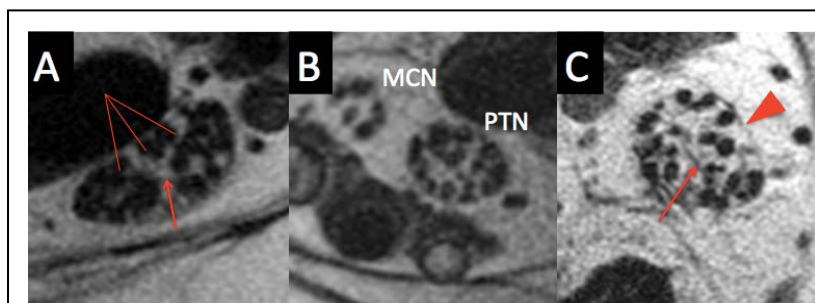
2D TSE T1-weighted with approximately 100 μ m resolution. Posterior tibial nerves at the ankle from different patients. [A] Suspected tarsal tunnel syndrome with mild neuropathy. [B] Mild diabetic neuropathy. [C] Severe amyloid related neuropathy. The fascicles (straight lines) are interspersed with a variable amount of epineurial fat, seen bright. Fibrous epineurium (long arrow) and paraneural fascia (arrowhead) are also seen, with low signal. Note the separation of the medial calcaneal nerve (MCN) branch of the posterior tibial nerve (PTN).
